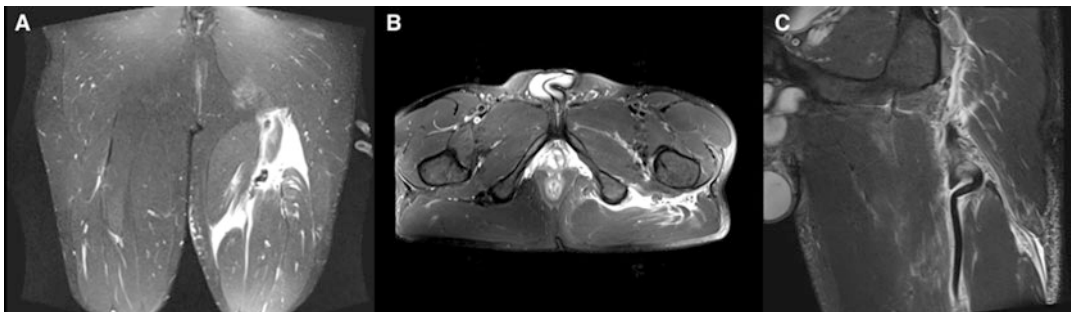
Coronal (a), axial (b), and sagittal (c) views of complete proximal hamstring avulsion in MRI
